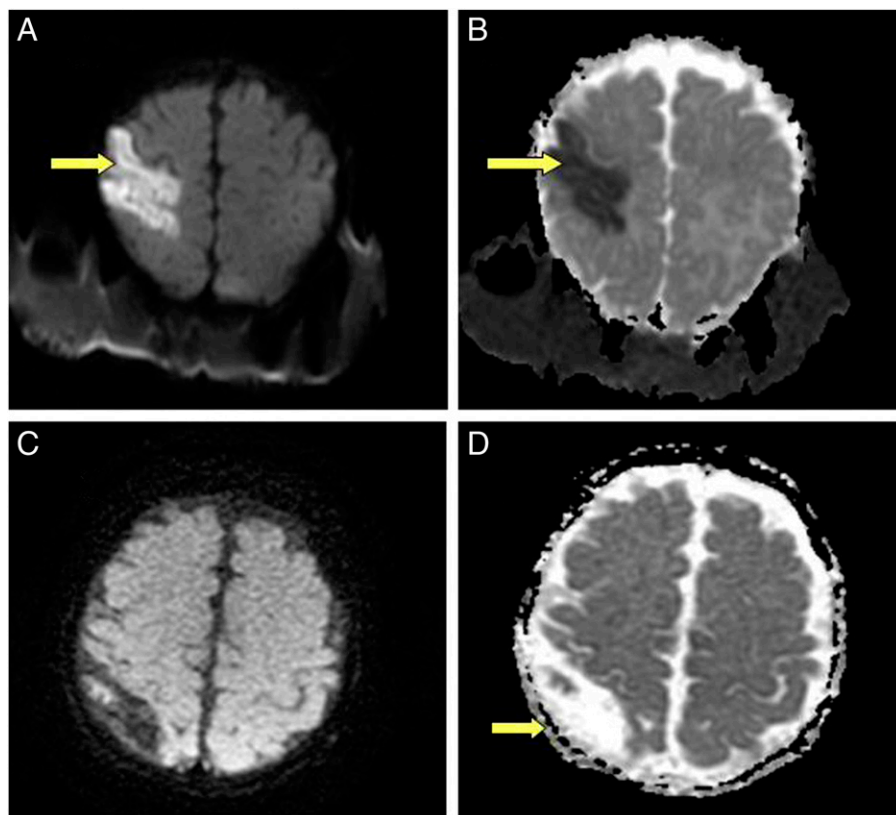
Magnetic resonance imaging of the brain. A and B. Diffusion-weighted image and apparent diffusion coefficient image demonstrate a focal, parenchymal, somewhat wedge-shaped diffusion restriction (yellow arrows) along the right precentral and postcentral gyrus. C and D. There is no diffusion restriction after treatment, but encephalomalacic changes (yellow arrow) are noted.
